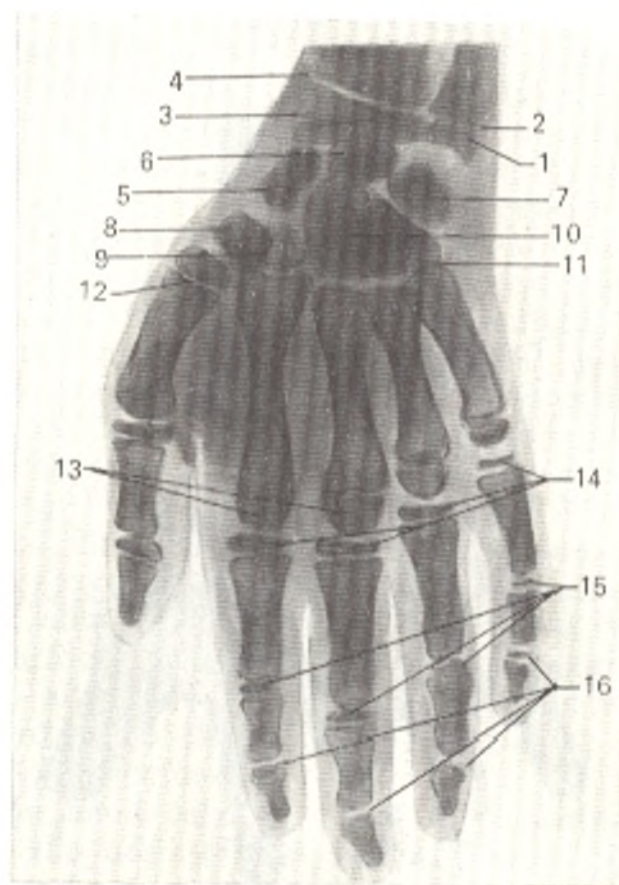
Radiograph of hand of a 9-year-old boy.
